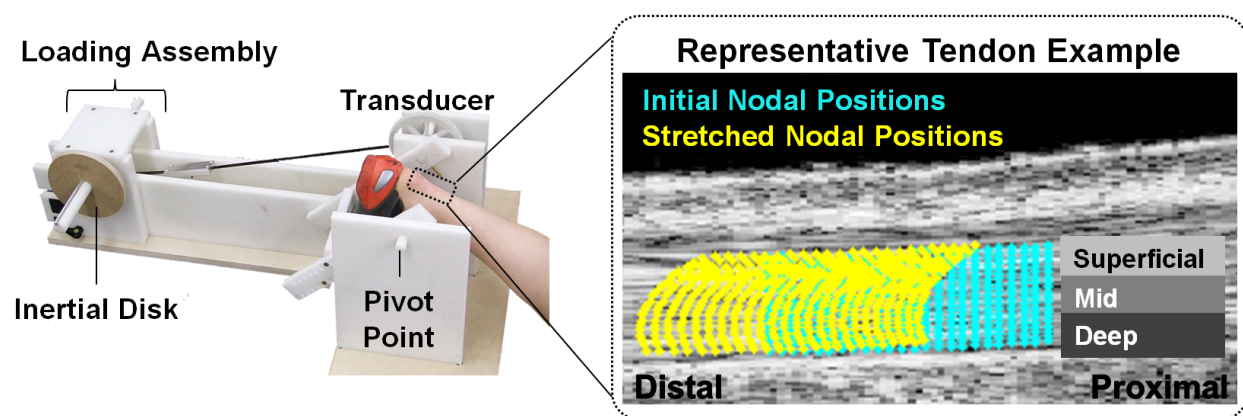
An overview of the experimental setup and image analysis. Inertial disks were used to induce eccentric plantarflexor contractions when moving from a plantarflexed to dorsiflexed position. An ultrasound transducer placed over the distal Achilles tendon was used to collect RF data throughout the cyclic trials. In post-hoc analysis, initial nodal positions were defined within the tendon from an image collected in the most plantarflexed position. Two-dimensional elastography was then used to track the subsequent motion of nodes located in superficial, mid and deep portions of the tendon.
